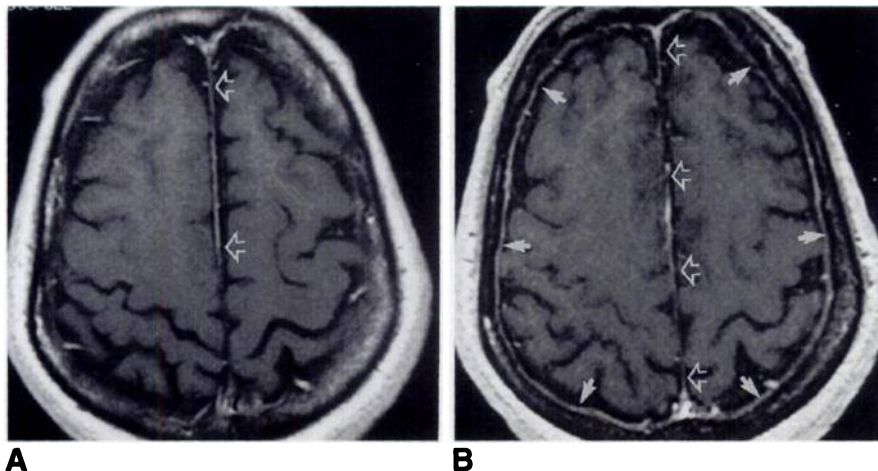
Corresponding contrast-enhanced 2DSE (A) and 3DGE (B) MR images at level of supraventricular white matter (level four) of a patient with normal meninges. Minimal meningeal enhancement is seen on 2DSE MR image, whereas 3DGE MR image shows continuous enhancement throughout meninges (closed arrows in B). Also note increased length of enhancement of falx cerebri (open arrows) and relative decreased signal intensity of diploic space on 3DGE image.
